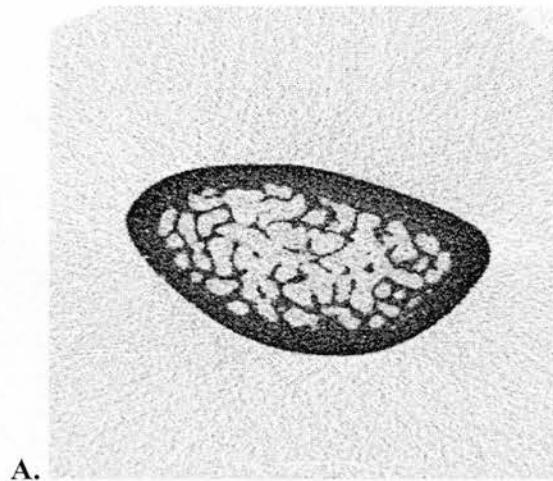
Two-dimensional images of the femoral metaphysis using micro-computed tomography. Representative 2D images derived from the μ CT analysis for (A) Control, (B) rhPTH and (C) rhGH.
